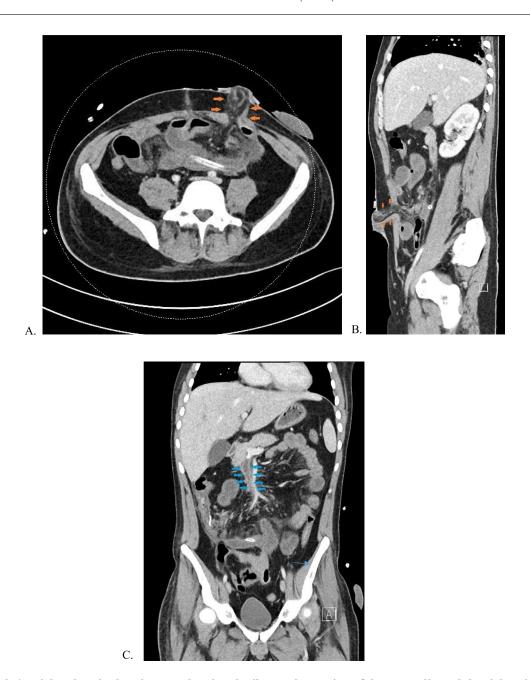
(A and B) Axial and sagittal CT images showing the ileocecal resection of the appendix and the right- sided ileostomy (orange arrows). The scan revealed slightly dilated small bowel loops with fluid towards the stoma. A percutaneous drain was placed, with the tip located between the liver and abdominal wall. (C) Coronal CT image demonstrating persisting thrombus in the SMV and its tributaries, without any signs of progression (blue arrows). The scan also showed regression of the abscess-like collection in the mesentery (Fig. 2 A and B).
